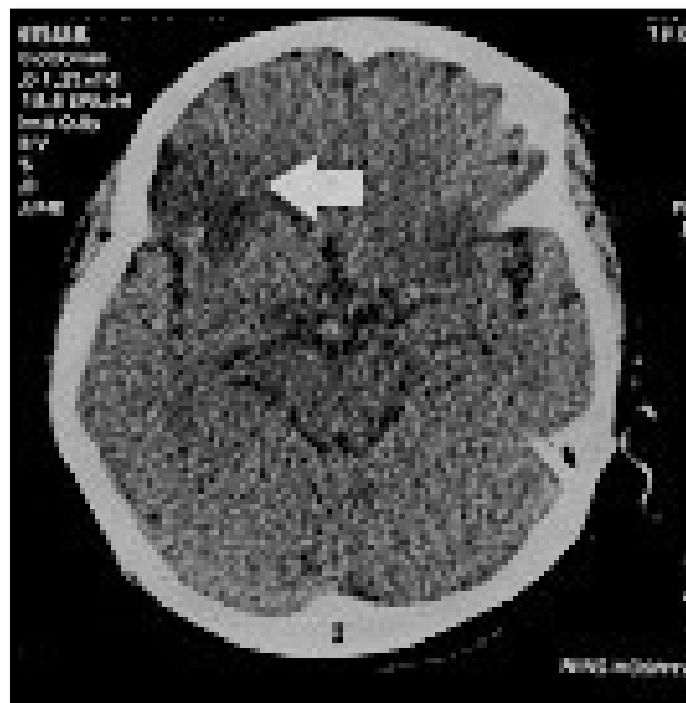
CT Image showing infract in the right frontal lobe
